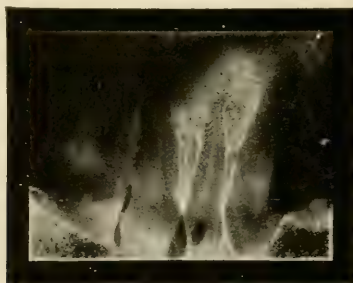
Alveolar abscess wrongly diagnosed as pyorrhea. (Radiograph by Rhein, of New York.)
